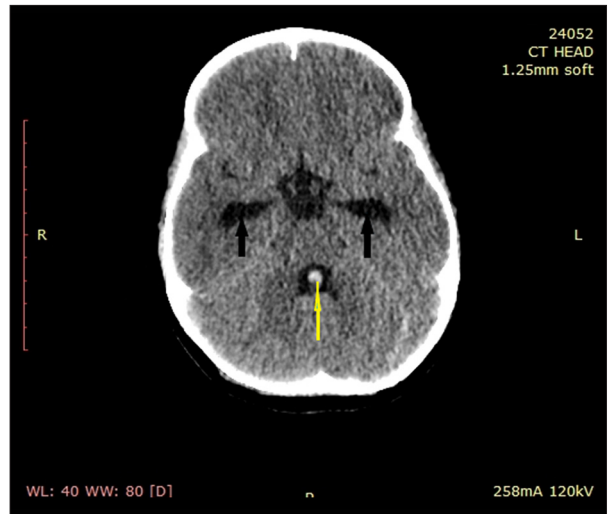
CT scan performed the following day depicting the persistence of the blood clot within the fourth ventricle and the incipient dilation of the temporal horns. CT – computed tomography.
